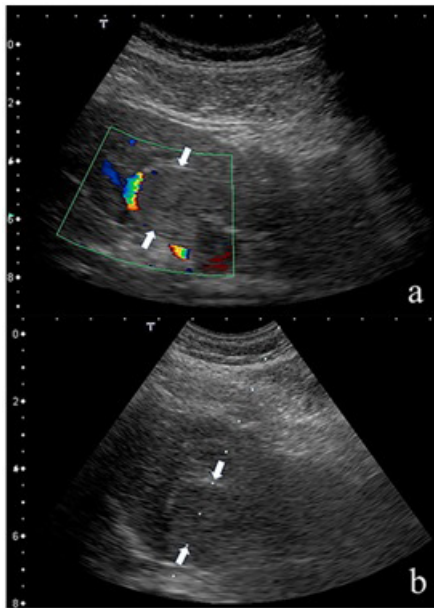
(a) Color Doppler ultrasonogram showing thrombosis (arrows) in the umbilical portion of the portal vein. (b) Ultrasonography-guided Chiba needle aspiration of the umbilical portion of the portal vein along (arrows) the puncture-guided line.
